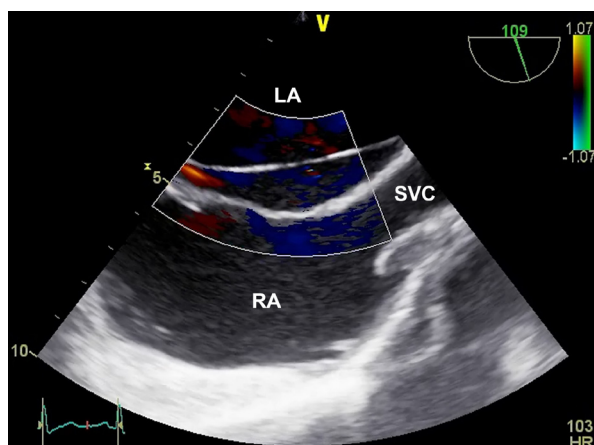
Two-dimensional transesophageal echocardiogram (midesophageal bicaval view) shows 2 parallel interatrial septa.
